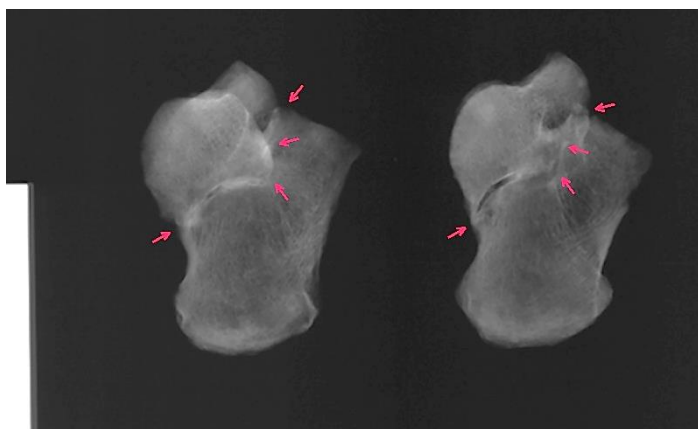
X-ray of both the calcaneus and talus.
